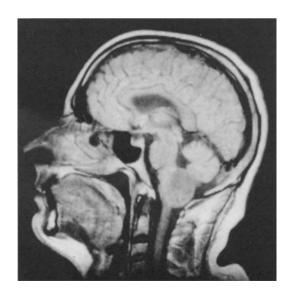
MRI of a 47-year-old patient with a pilocytic astrocytoma of the brain stem, which was subtotally removed
